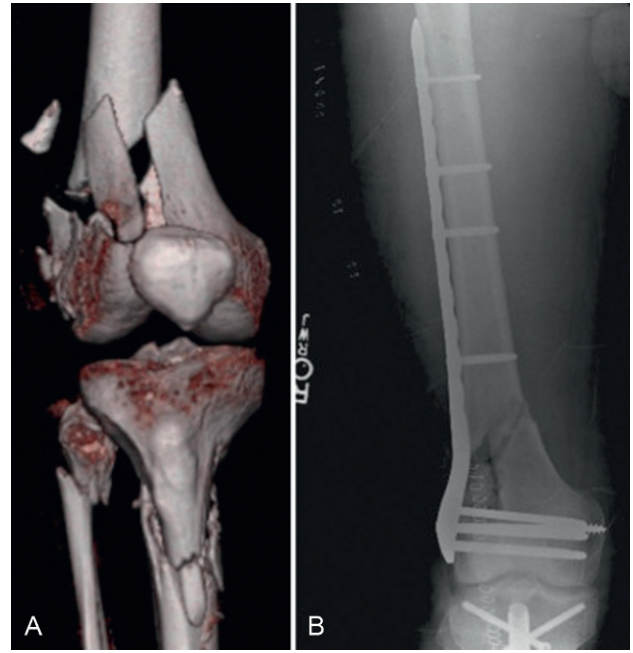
Comminuted fracture of the femur with internal fixation. (A) Preoperative three-dimensional reconstruction of comminuted distal femur fracture. (B) Postoperative x-ray after surgery with lateral locked plate. (From Stancil R, Haidukewych GJ, Sassoon AA. Distal femur fractures. In: Scott WN, ed. *Insall & Scott Surgery of the Knee*, 6th ed. Philadelphia: Elsevier; 2018.)
